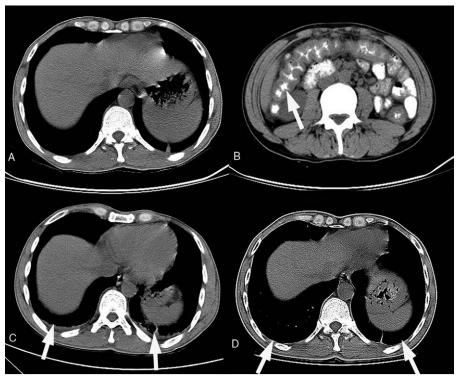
Thorax and abdomen CT images. (A) Image of lung before treatment was normal. (B) Mild dilatation and wall thickening of terminal ileum is shown in abdomen image (arrow). (C) 2-sided basal pleural effusion is shown in lung image (arrows). (D) Pleural effusion was absorbed (arrows).
